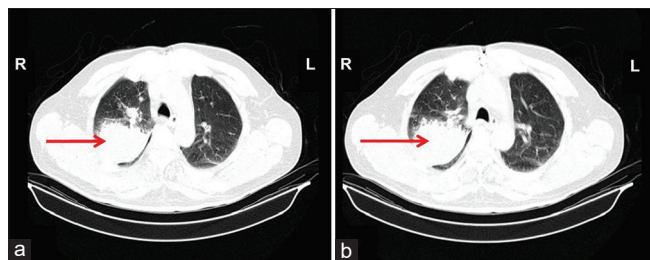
The results of computed tomography scan of the lung with granulomatosis with polyangiitis (a and b). There is a big pulmonary mass in the right lung indicated by arrows
